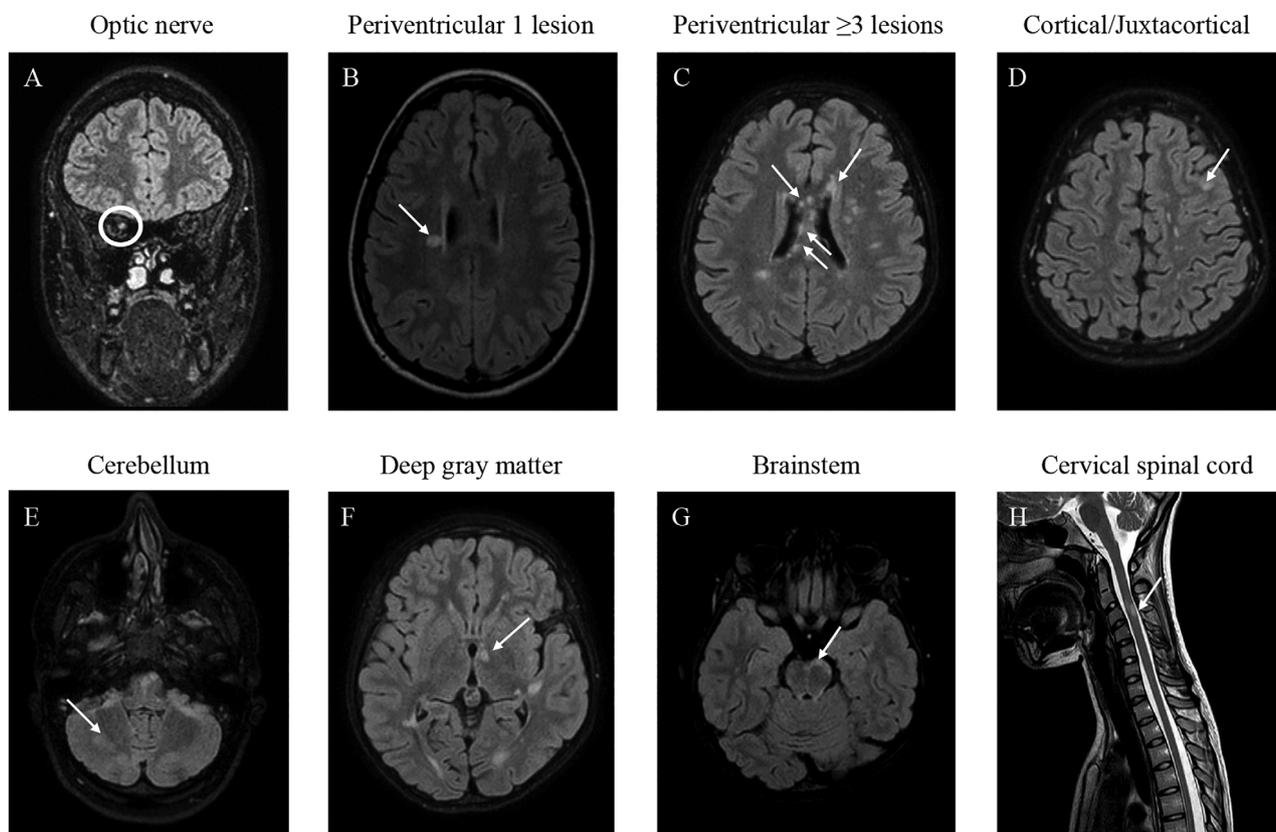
Lesion distribution. The pictures are representative of the 7 brain regions considered in the study. Lesions located in the following compartments (highlighted by white circles and arrows) were detected on fluid-attenuated inversion recovery (FLAIR) magnetic resonance imaging (MRI) sequences: (A) optic nerve; (B) periventricular region (1 lesion); (C) periventricular region (3 or more lesions); (D) cortical/juxtacortical region; (E) cerebellum; (F) deep gray matter; (G) brainstem; and (H) cervical cord.
